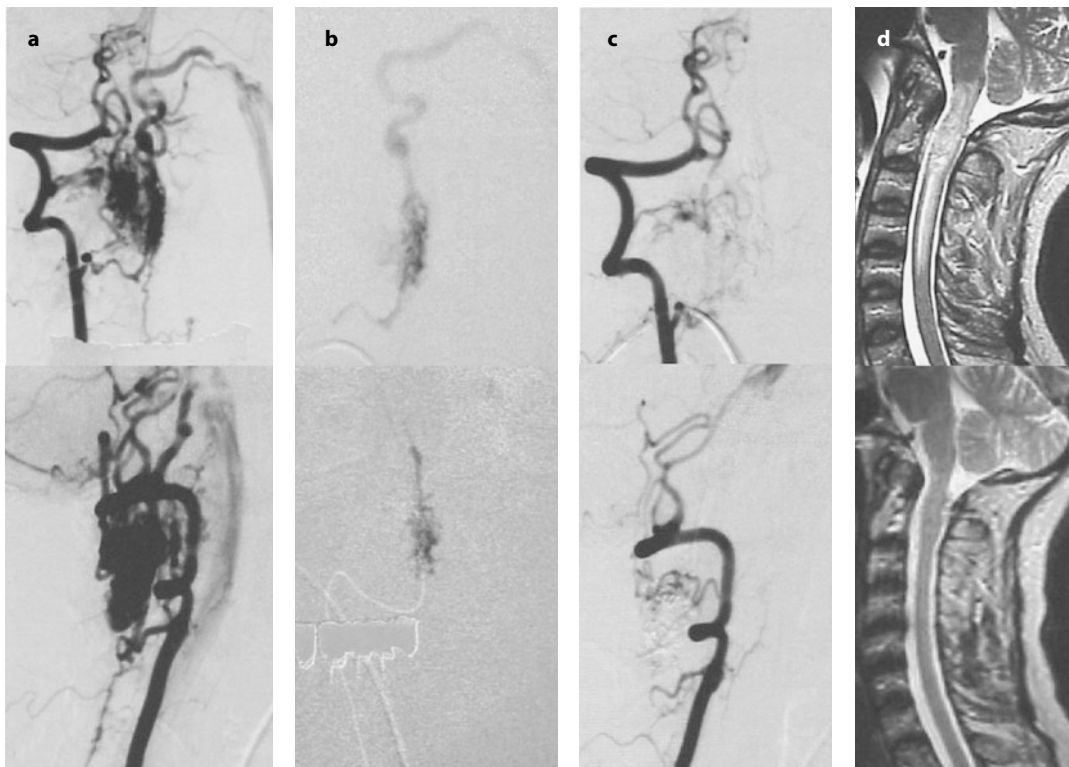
Glomus-type spinal cord AVM (type II). (a) Anteroposterior and lateral view of a C1–C2 intramedullary diffuse arteriovenous malformation fed by segmental branches of the right and left vertebral arteries. (b, c) Super-selective angiography of a right segmental feeder and NBCA-selective injection. (d) T2 sagittal MRI undertaken the following day shows diffuse myelopathy that recovered at 6-months. The patient showed good recovery with residual neurological deficits
